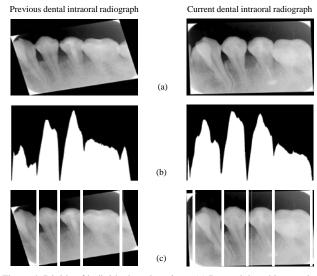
Divide of individual tooth regions: (a) Rotated dental intraoral radiograph, (b) Average pixel values on each X-coordinate, (c) individual divided tooth regions
